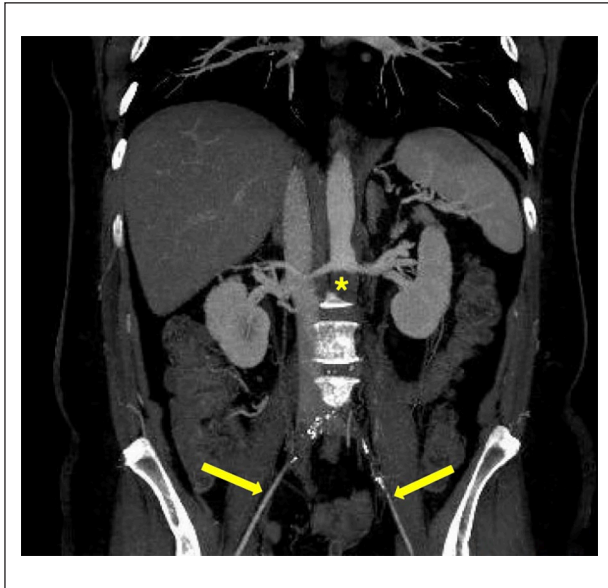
Coronal view of the CT angiogram revealing infrarenal aortic occlusion (*) with reconstitution of the external iliac arteries (arrows). Bilateral renal arteries were free of thrombus with normal opacification of the kidneys.
